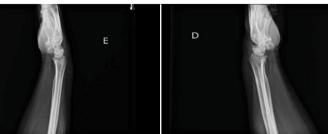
Lateral view: radiographic image of the left and right hand and wrist, respectively.
